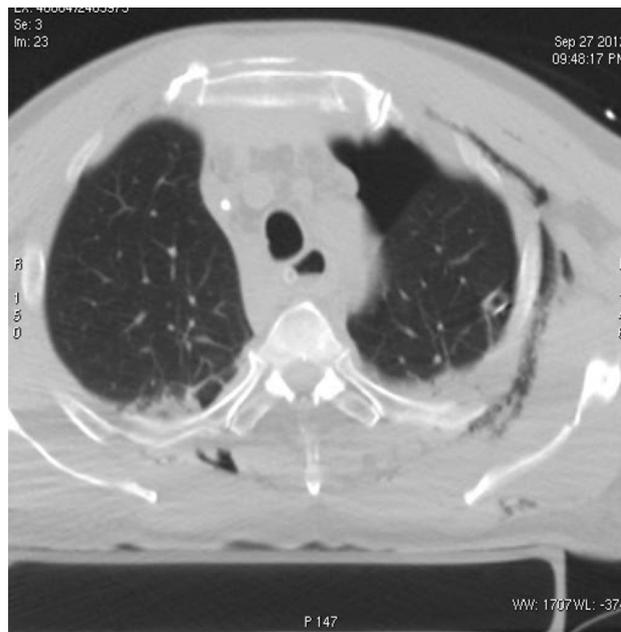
Thoracic multidetector computed tomography (MDCT): confirmation of mild left pneumothorax in stabbed pregnant patient (24 years old); thoracic emphysema and haemothorax are also visible
